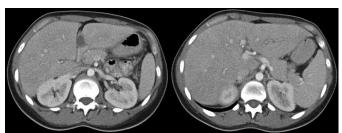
Computed tomography confirming resolution of acute pancreatitis.
